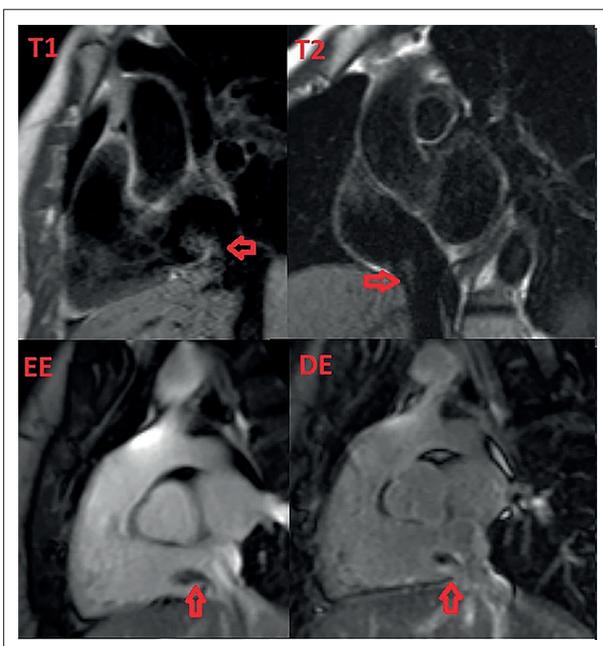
Cardiac magnetic resonance imaging showing the right atrial mass.
